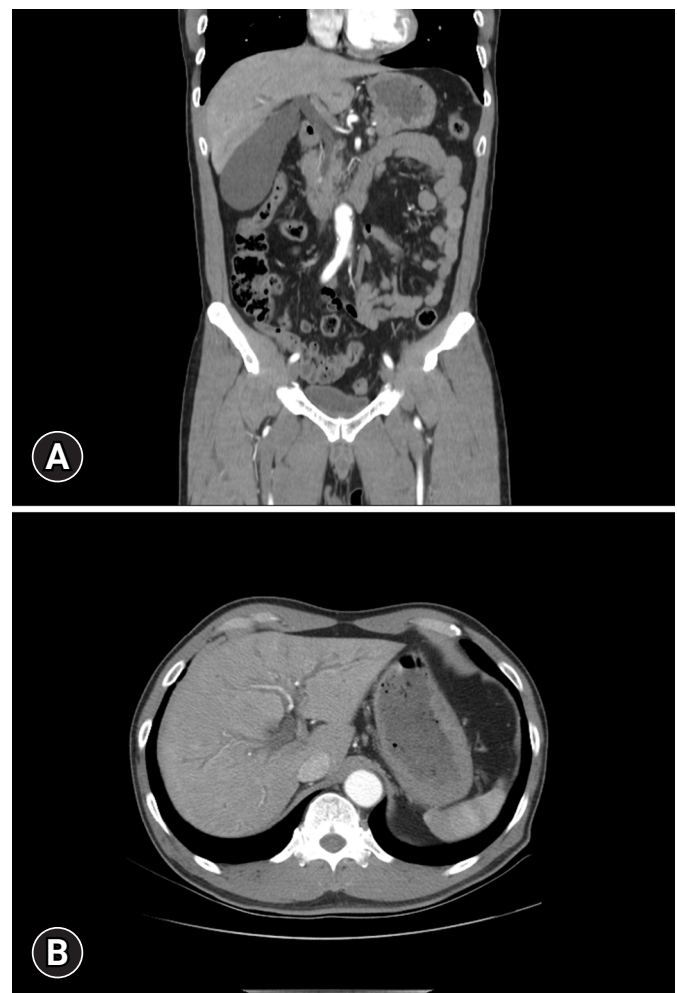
Abdominal computed tomography findings. (A) Coronal view: a radiopaque lesion on the distal portion of the common bile duct. (B) Axial view: diffusely dilated bile duct from the peripheral to the distal portion.
